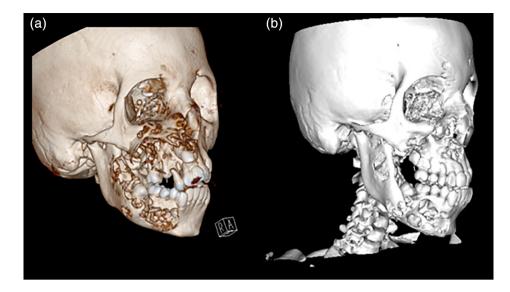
(a–d) Pre-surgery computed tomography scan revealed bilateral multilocular expansive lesions (white arrows) with loss of the normal anatomy of the maxilar and mandible
